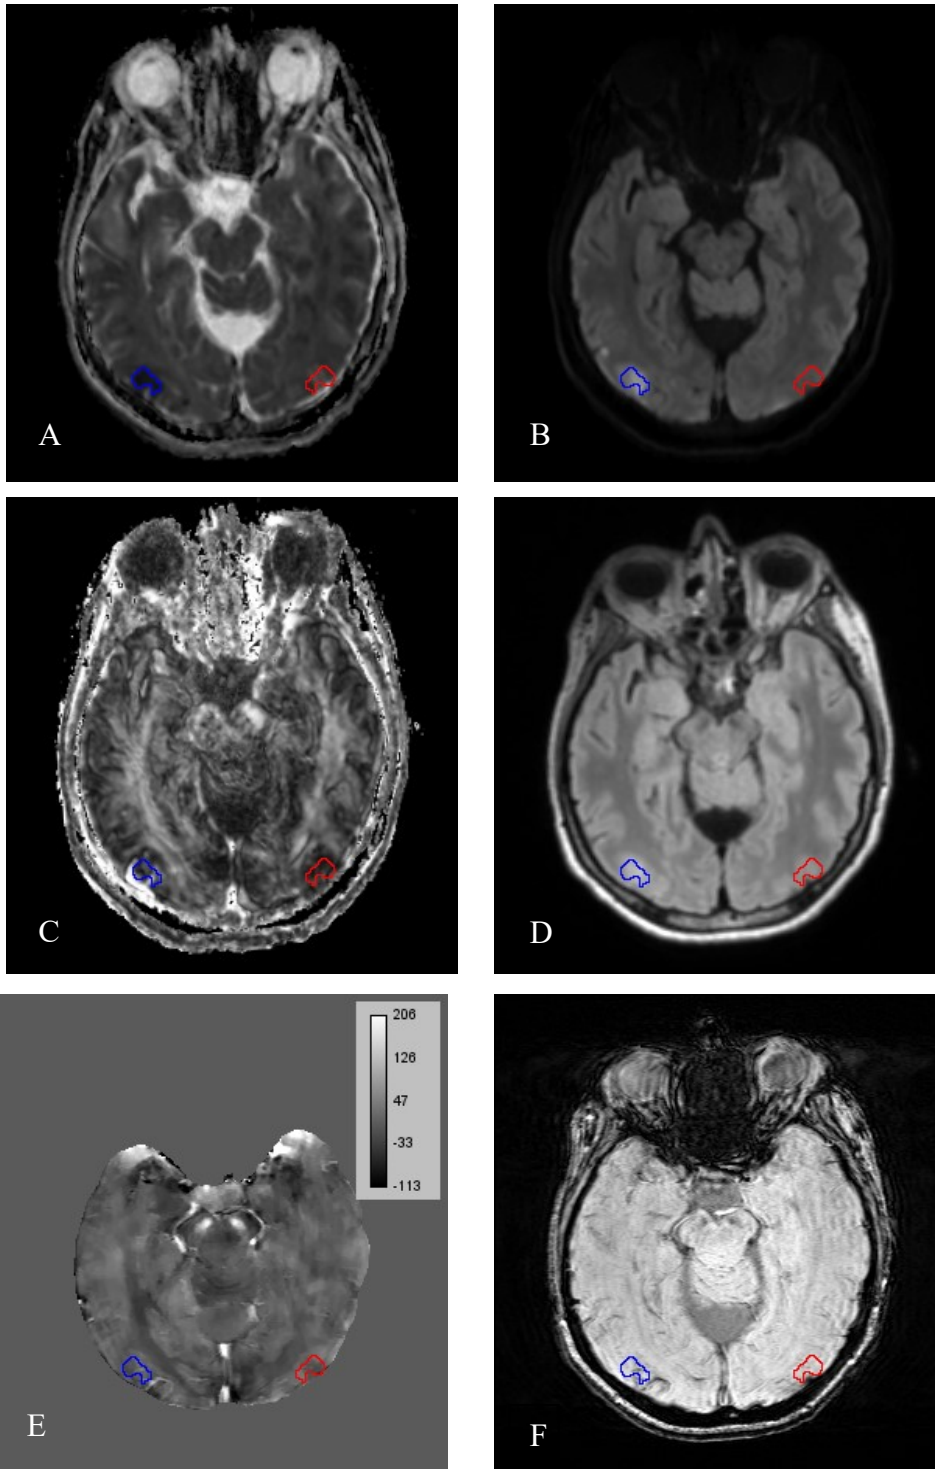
Grey matter tissue ROI on MD map (A), DWI (B), FA map (C), MPRAGE (D), QSM in ppb (E), SWI (F). Size of the lesion was 78.46 mm². Blue ROI is from infarcted region and red ROI is from the contralateral homologous region.
